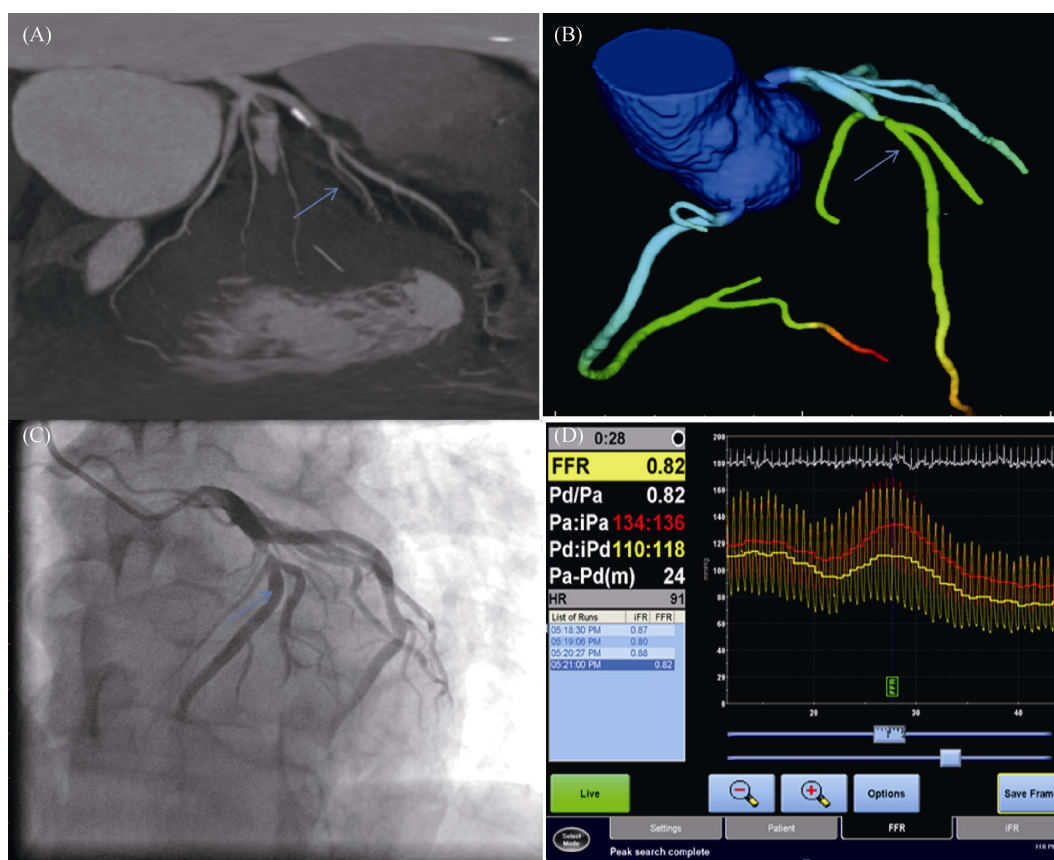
Representative examples of subjects from the study. (A): Multiplanar reformat of coronary computed tomography (CT) angiogram; (B): the left anterior descending artery (blue arrow) and DEEPVESSEL-FFR 0.81; (C): invasive coronary angiogram; and (D): invasive FFR measurement, a measured FFR value of 0.81. FFR: fractional flow reserve.
